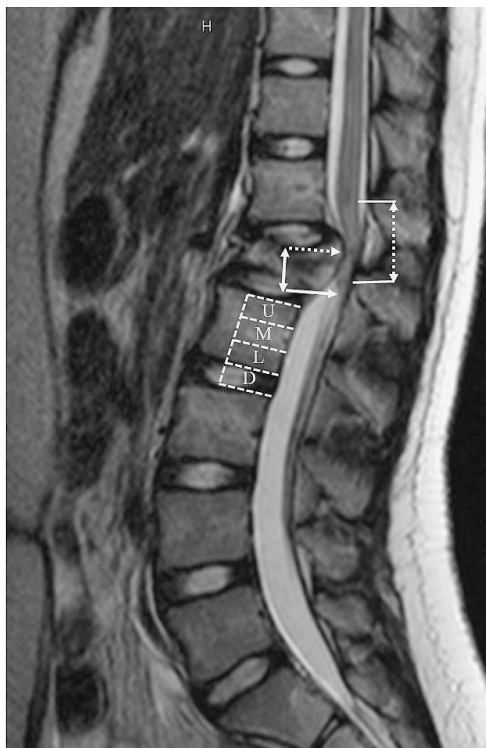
The interval from the terminal end of the spinal cord to the narrowest level of the spinal canal was measured. The narrowest level of the spinal canal was ordered according to the interval as follows: epiconus, conus medullaris, and cauda equina. Solid single arrow: terminal end of the spinal cord. Dotted single arrow: the narrowest level of the spinal canal. Solid double-headed arrow: the interval from the terminal end of the spinal cord to the narrowest level. Dotted double-headed arrow: high T2-weighted signal intensity area. U, upper third of the vertebral body; M, middle third; L, lower third; D, disc.
